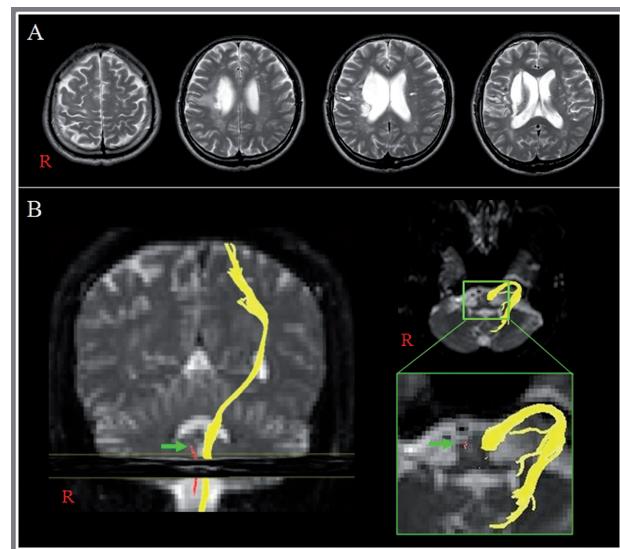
(A) T2-weighted brain magnetic resonance images show a leukomalactic lesion in the right corona radiata and basal ganglia level. (B) Diffusion tensor tractography for the corticospinal tract (CST). The CST of the left hemisphere originated from the primary sensori-motor cortex and descended through the known CST pathway. However, the CST of the right hemisphere showed a disruption with Wallerian degeneration to the pontomedullary junction (arrow).
